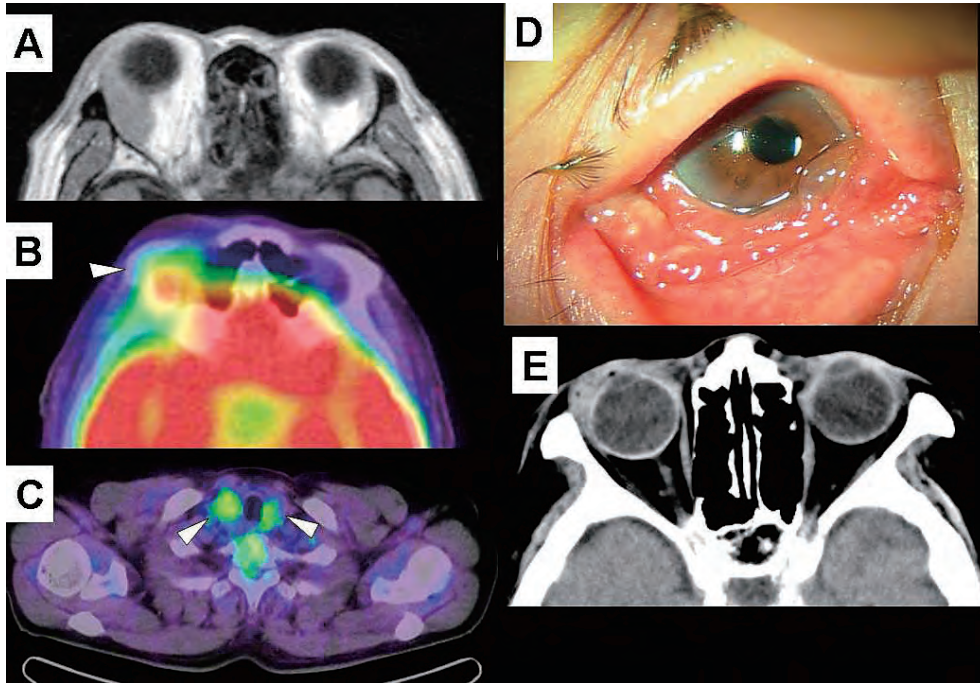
Case 3 (left column) and Case 8 (right column). A 60-year-old man presents with a right orbital mass on T1-weighted magnetic resonance imaging (6A) and Hashimoto thyroiditis. Fluorodeoxyglucose positron emission tomography fused with computed tomography shows high uptake in the right orbit (arrowhead in 6B, the maximum standardized uptake value: SUVmax = 7.38) and bilateral thyroids (arrowheads in 6C, SUVmax = 3.69). A 91-year-old woman develops right bulbar conjunctival mass (6D), which is localized superficially on computed tomographic scan (6E).
